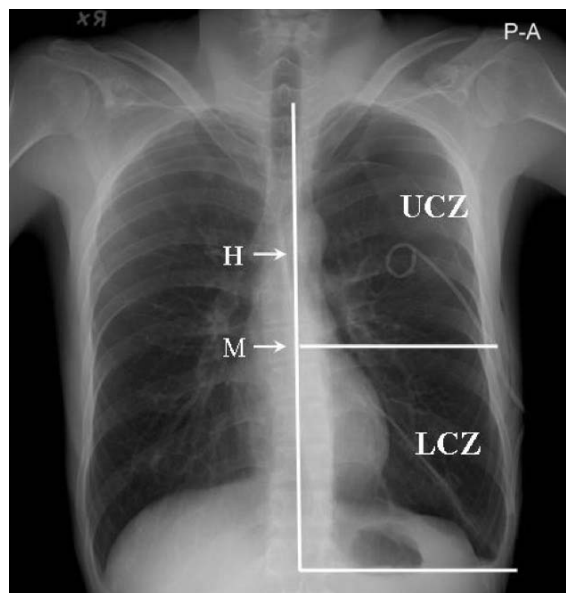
Chest radiograph shows left side pneumothorax with pigtail tube drainage in the upper chest zone. UCZ was defined as the upper half of the hemithorax. UCZ = upper chest zone; LCZ = lower chest zone.
